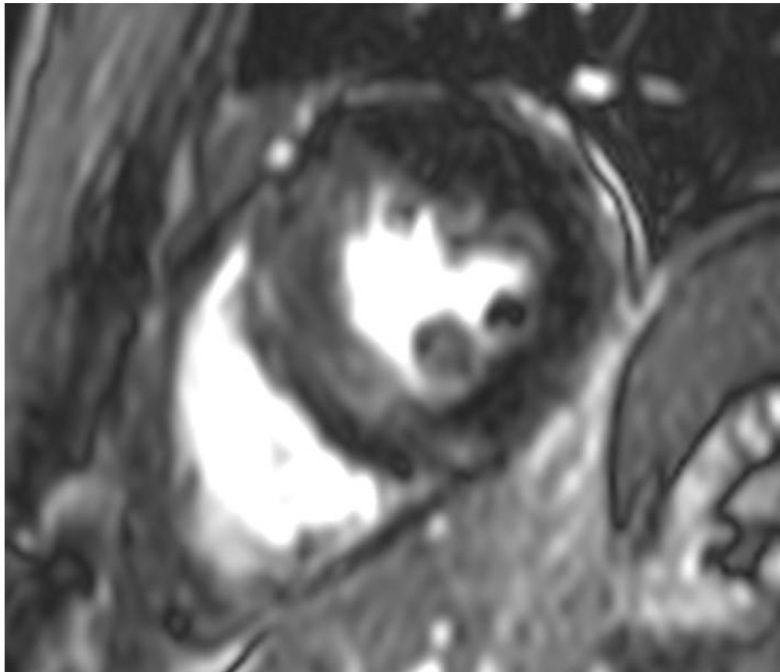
Cardiac magnetic resonance imaging shows patchy non-ischemic late gadolinium enhancement in the interventricular septum.
